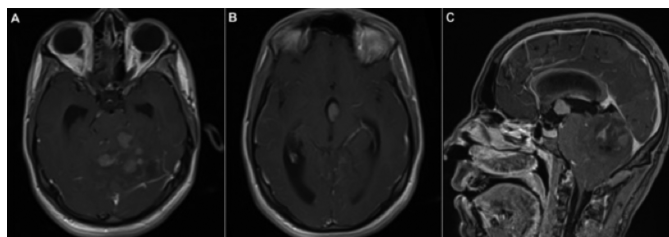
Contrast-enhanced T1-weighted Magnetic Resonance Imaging (MRI) images preoperatively. (A) Axial, cerebellar tumour; (B) Axial, third ventricular tumor; (C) Sagittal, both tumours can be seen in the same image.
